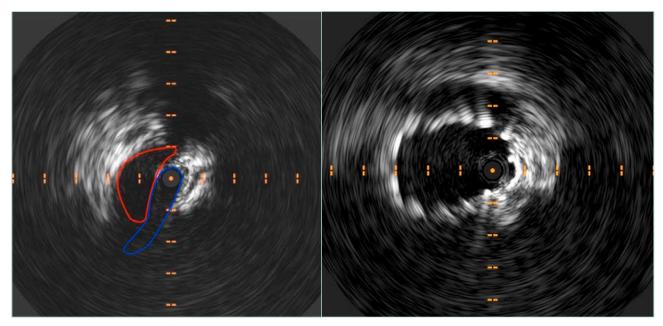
Intravascular ultrasound (IVUS) showing preoperative compression at May-Thurner's point and subsequent restored patency post stenting.
